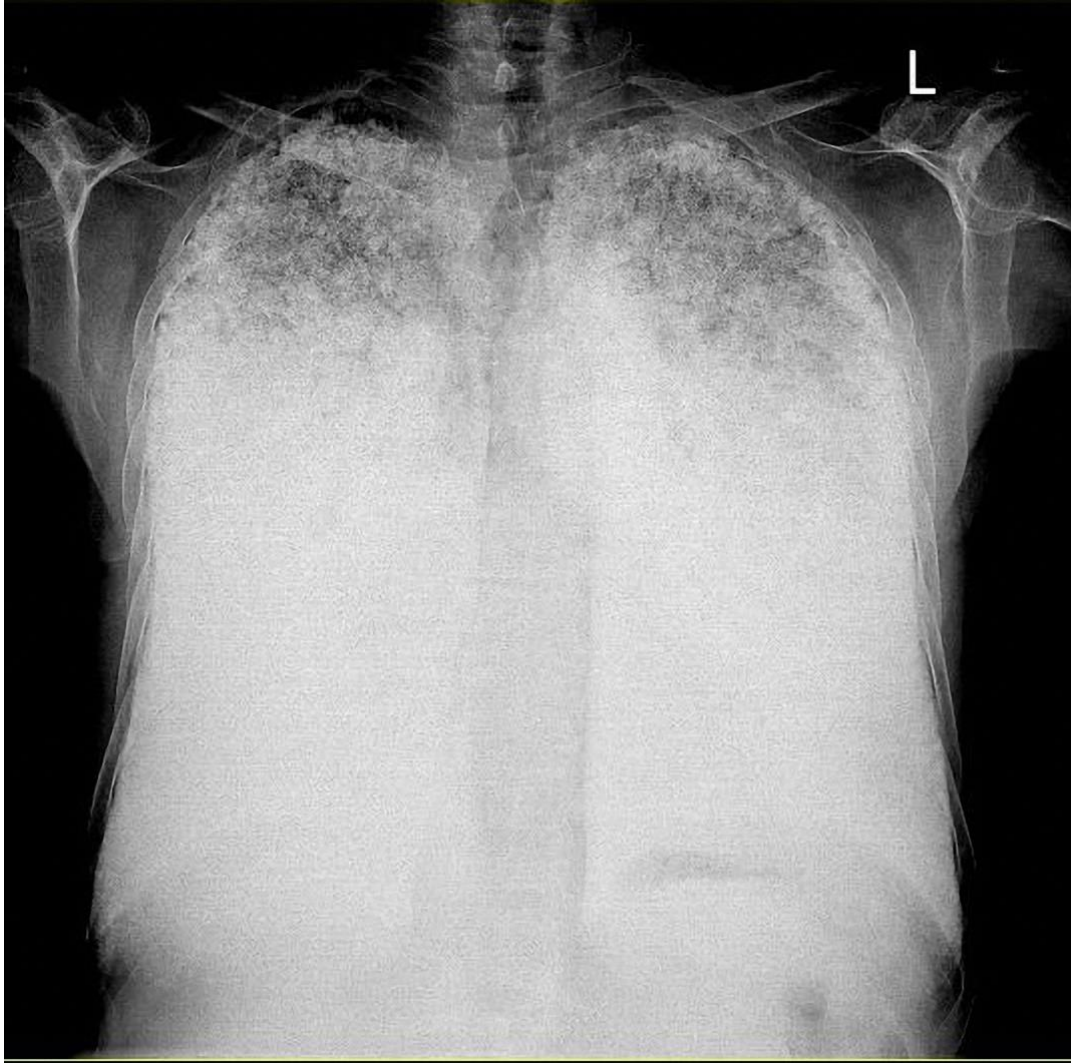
Chest X-ray showed diffuse alveolar nodular pattern (sand-storm).
